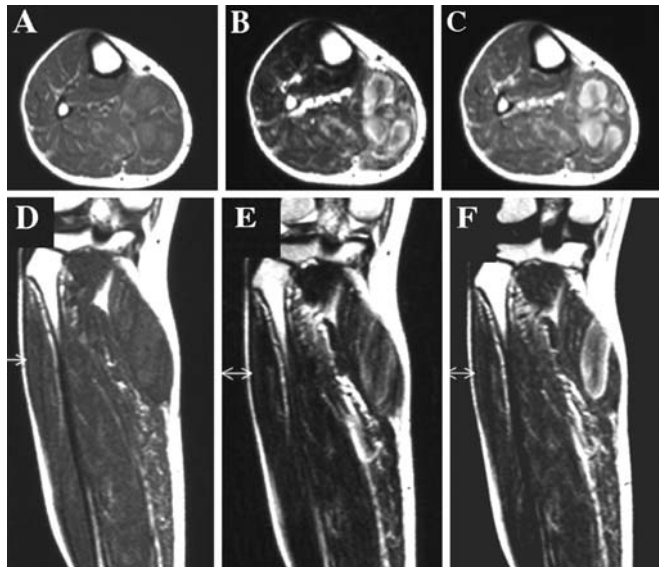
A T1-weighted (TR, 350 ms; TE, 14 ms) axial magnetic resonance (MR) image. The mass exhibited heterogeneous and slightly elevated signal intensity. B T2-weighted (TR, 3000 ms; TE, 105 ms) axial image. The periphery of the lesion exhibited very high signal intensity, while the center demonstrated heterogeneous low- to isointensity. C Gadolinium–diethylenetriamine penta-acetic acid (DTPA)-enhanced T1-weighted image. The periphery of the mass was markedly enhanced. D T1-weighted (TR, 350 ms; TE, 14 ms) coronal image. The coronal MR image demonstrated findings similar to those of axial images, but allowed better visualization of tumor localization along the gastrocnemius muscle fibers. E T2-weighted (TR, 3000 ms; TE, 105 ms) coronal image. F Gadolinium–DTPA-enhanced T1-weighted coronal image
